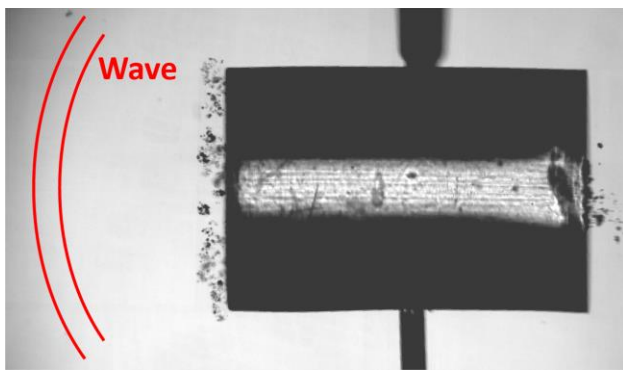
High-speed image of cavitation bubbles excited on the proximal surface of a cylindrical stone model during the passage of the focused ultrasound wave. The length of the stone is 10 mm.
